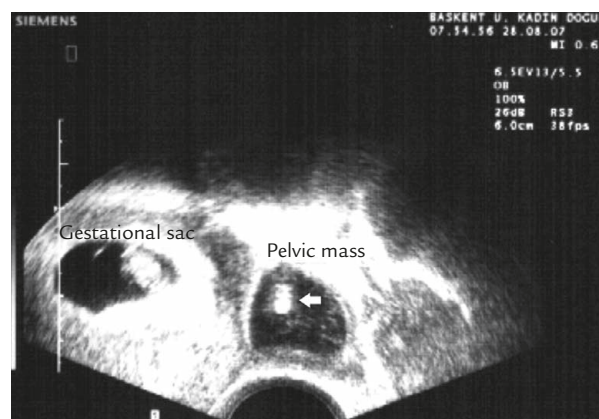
Ultrasonography revealed gestational sac and pelvic mass. Arrow indicates part of the intrauterine device.
